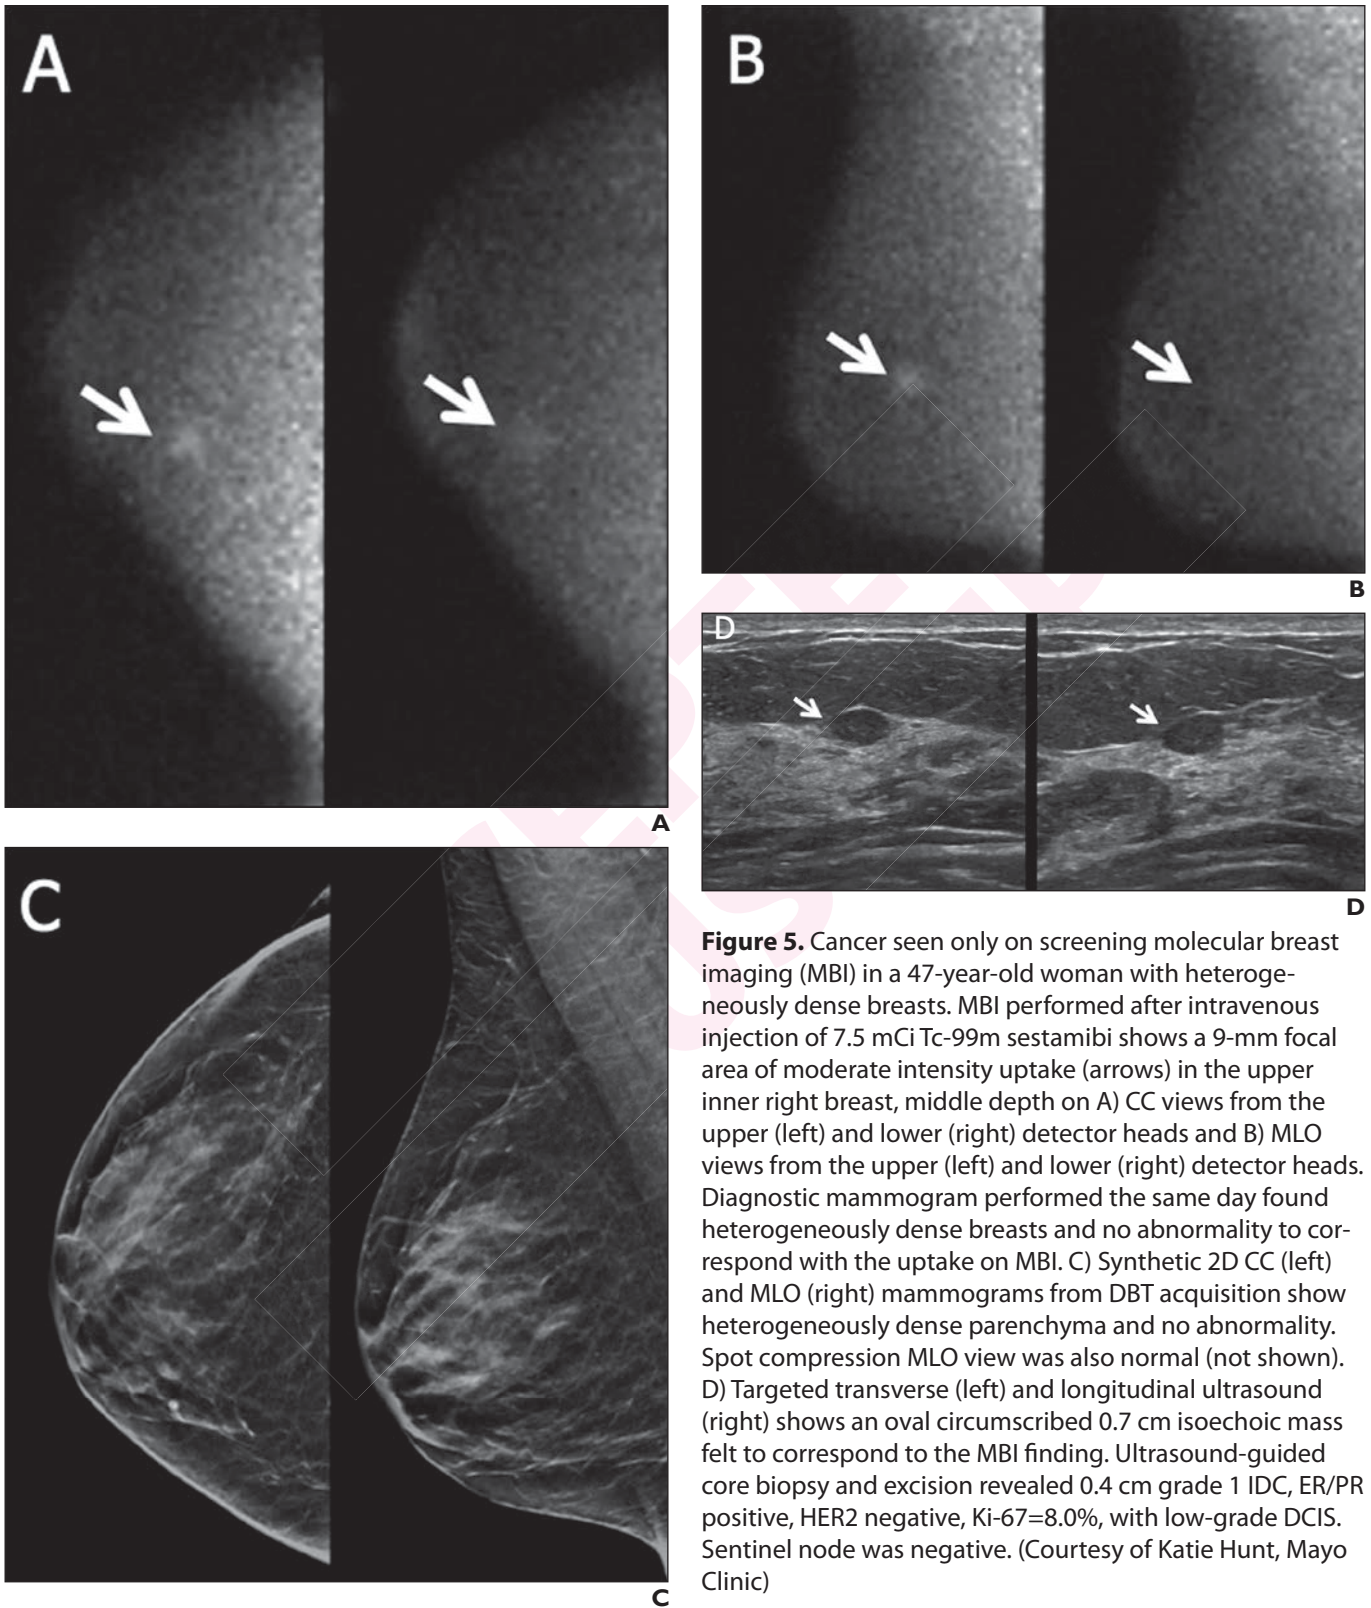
Cancer seen only on screening molecular breast imaging (MBI) in a 47-year-old woman with heterogeneously dense breasts. MBI performed after intravenous injection of 7.5 mCi Tc-99m sestamibi shows a 9-mm focal area of moderate intensity uptake (arrows) in the upper inner right breast, middle depth on A) CC views from the upper (left) and lower (right) detector heads and B) MLO views from the upper (left) and lower (right) detector heads. Diagnostic mammogram performed the same day found heterogeneously dense breasts and no abnormality to correspond with the uptake on MBI. C) Synthetic 2D CC (left) and MLO (right) mammograms from DBT acquisition show heterogeneously dense parenchyma and no abnormality. Spot compression MLO view was also normal (not shown). D) Targeted transverse (left) and longitudinal ultrasound (right) shows an oval circumscribed 0.7 cm isoechoic mass felt to correspond to the MBI finding. Ultrasound-guided core biopsy and excision revealed 0.4 cm grade 1 IDC, ER/PR positive, HER2 negative, Ki-67=8.0%, with low-grade DCIS. Sentinel node was negative. (Courtesy of Katie Hunt, Mayo Clinic)
